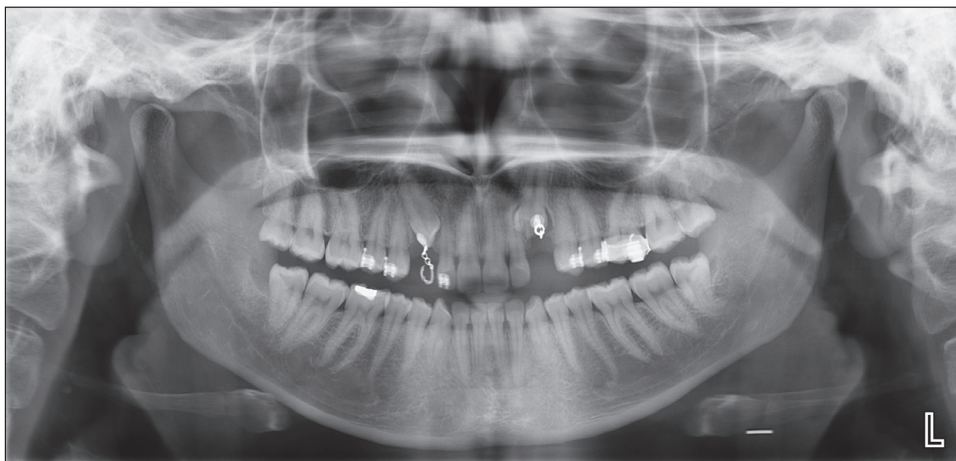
Pre-operative orthopantomographic (OPTG) image of the patient.
